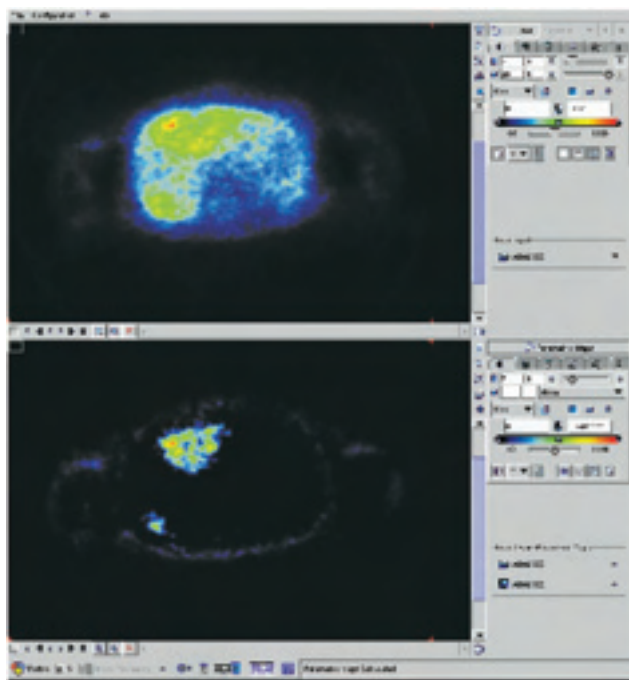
SUV image (upper row) and parametric image of the ^{18}F -FDG metabolism (lower row) in a patient with multiple liver metastases of a carcinoid. The delineation of the liver metastases is clearly superior in the parametric image as compared to the SUV image. The parametric image represents primarily the phosphorylated part of ^{18}F -FDG in the dorsolateral part of the right liver lobe.
